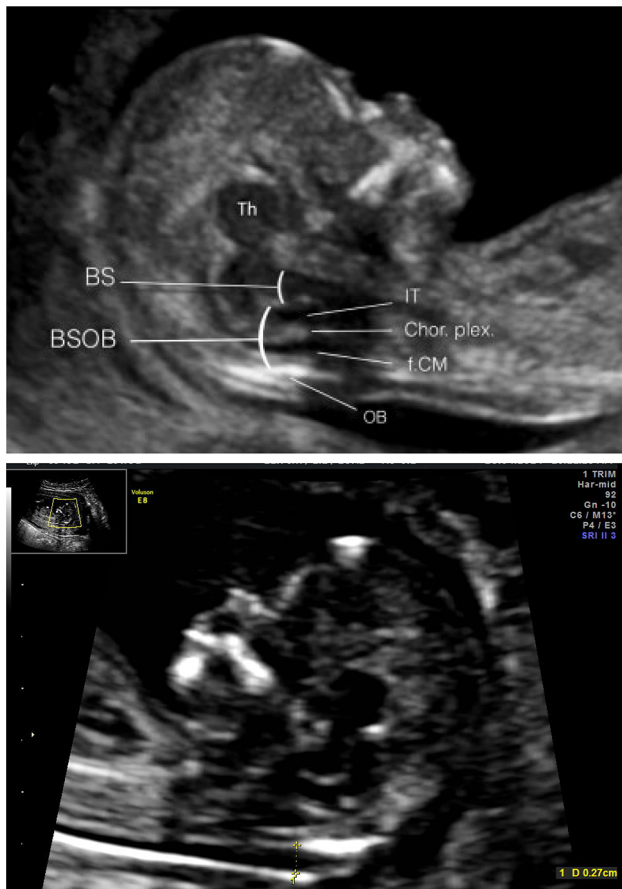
Ultrasound image showing landmarks for brainstem and brainstem to occipital bone distance
